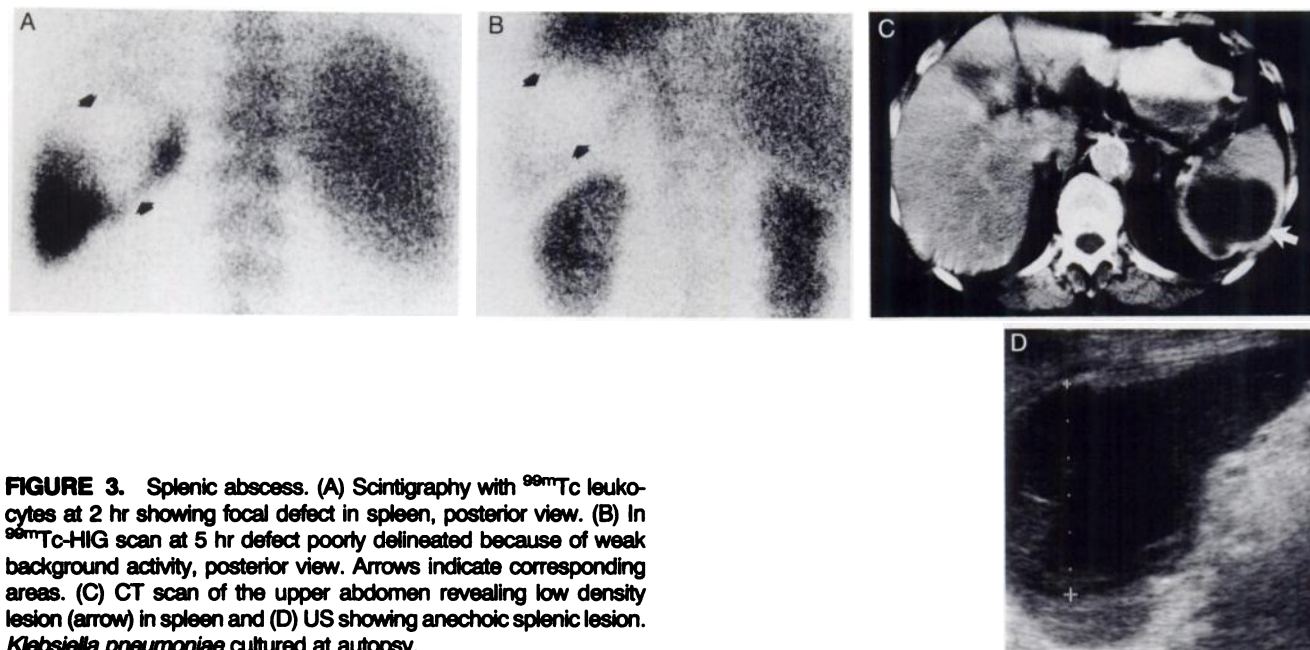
Splenic abscess. (A) Scintigraphy with ^{99m}Tc leukocytes at 2 hr showing focal defect in spleen, posterior view. (B) In ^{99m}Tc -HIG scan at 5 hr defect poorly delineated because of weak background activity, posterior view. Arrows indicate corresponding areas. (C) CT scan of the upper abdomen revealing low density lesion (arrow) in spleen and (D) US showing anechoic splenic lesion. *Klebsiella pneumoniae* cultured at autopsy.
